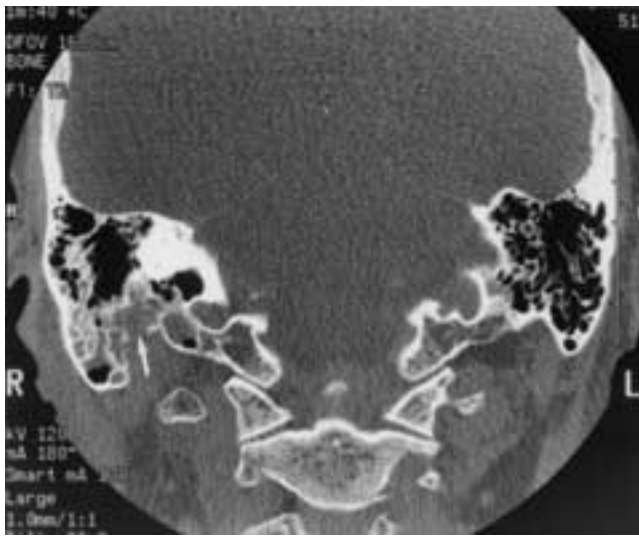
Squamous cell carcinoma of the right parotid gland with CT bone findings suggesting PNS along the descending facial nerve and stylomastoid foramen. The coronal CT bone window shows bone destruction at the stylomastoid foramen (*arrow*). The facial nerve canal was explored at surgery, and the nerve was found to be normal. These bone changes, though consistent with PNS, were secondary to the direct effects of the primary tumor.
